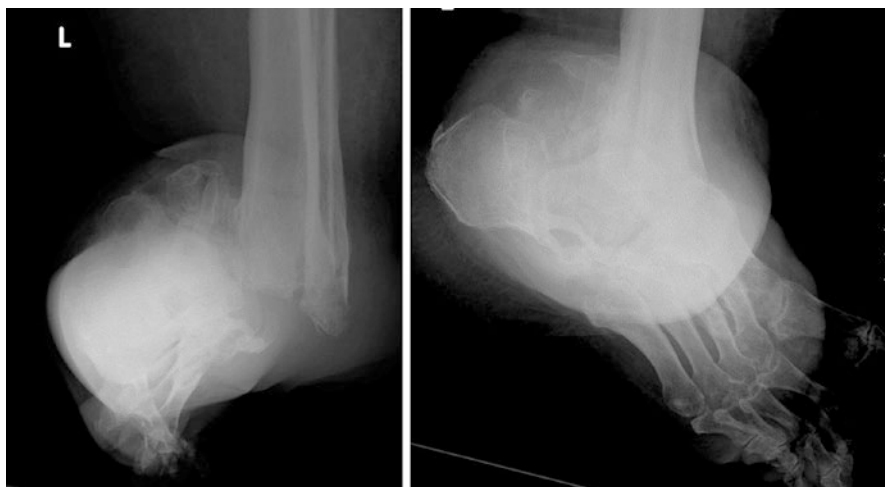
An AP and lateral radiographs of the left foot of a 64 years old diabetic female with advanced neuropathic foot changes involving mainly the hindfoot. These include severe tibio-talar joint dislocation as well as bone and joint destruction, disorganization, debris and increased bone density
